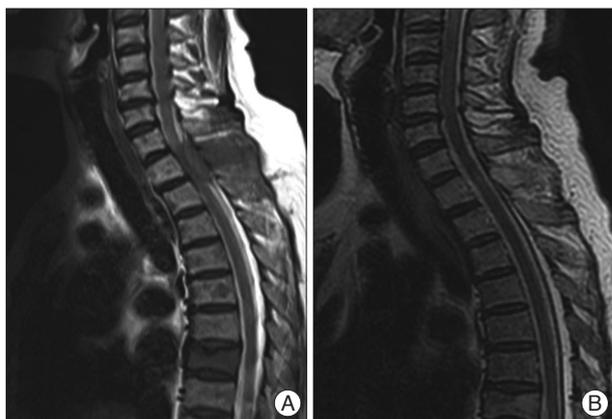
Case 1. A : Sagittal T2-weighted magnetic resonance image (MRI) of the spine showing posterior epidural mass extending from the C7 to T1 vertebra. Multiple marrow signal changes are noted at the vertebral body. B : Follow-up MRI obtained 1 month after radiotherapy shows a complete epidural tumor response.
